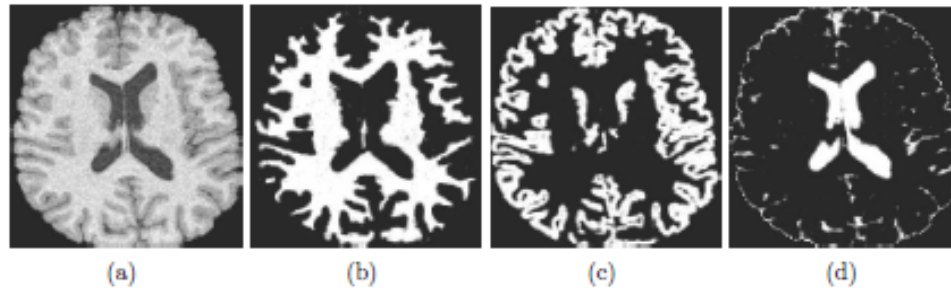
Partial volume segmentation of a high resolution brain MRI. (a) Input data, (b) expected fraction of white matter, (c) grey matter, and (d) cerebrospinal fluid [1].
